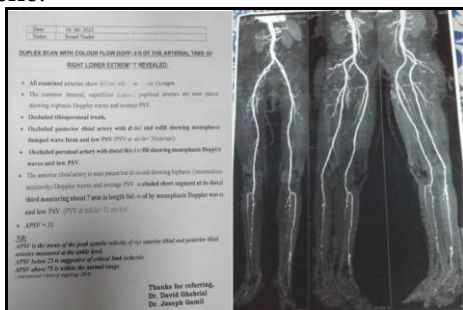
Arterial duplex and CT angiography was done showing: Patent origin of ATA then attenuated Occluded PTA from its origin with no distal end refillattenuated perianal artery Occluded pedal arch.
